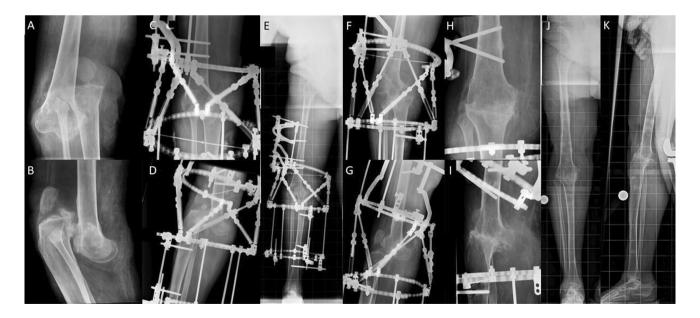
X-rays of knee fusion done for chronic right knee dislocation. A and B Anteroposterior and lateral knee views of the chronically dislocated knee; C, D and E Anteroposterior, lateral and full length lower extremity views 5 days after application of circular external fixation hexapod frame; F and G Anteroposterior and lateral knee views obtained 3 months following distraction to regain the soft tissue length; H and I Anteroposterior and lateral knee views at the end of circular external fixation frame treatment; J and K Anteroposterior and lateral full length lower extremity views obtained 14 months following frame removal
